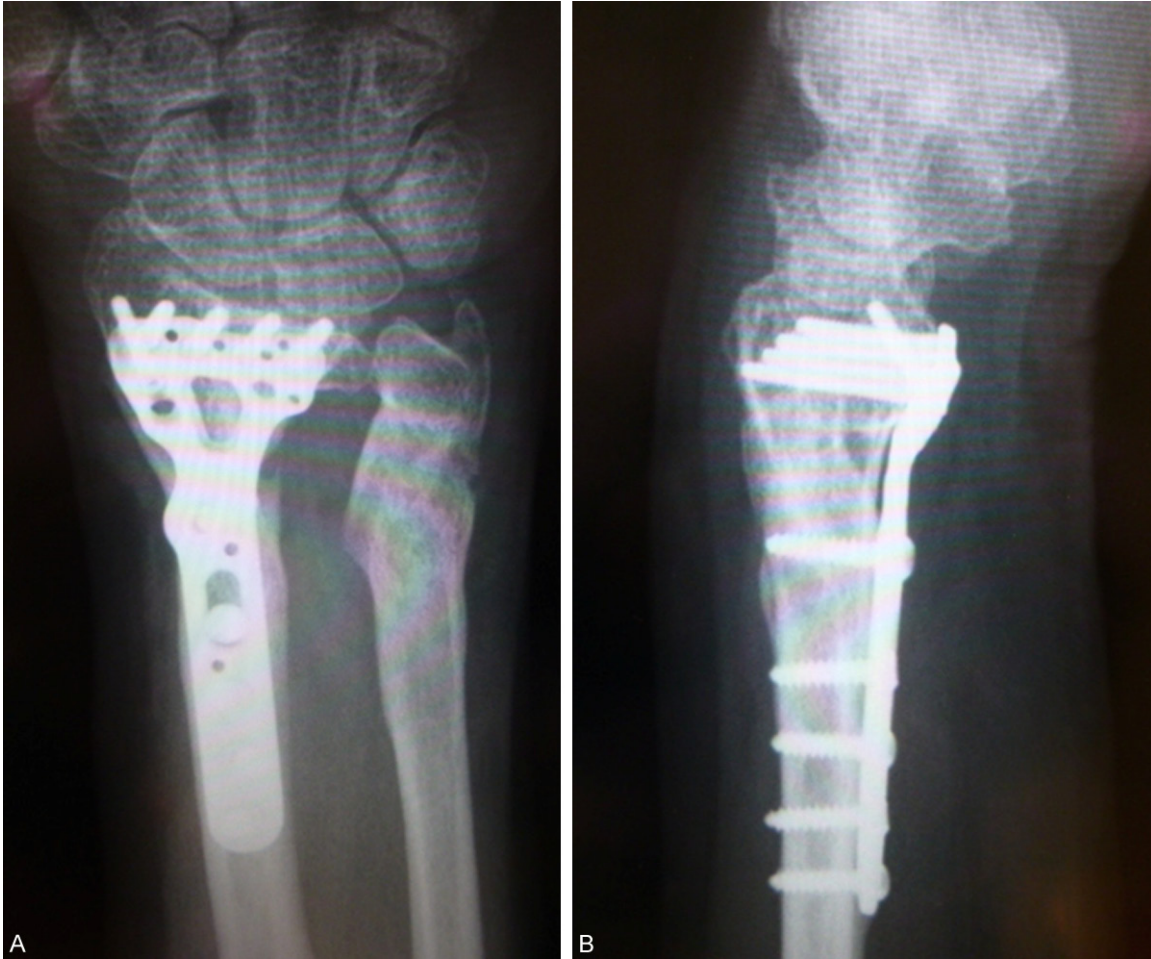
Plain radiography on the final follow-up. A: Frontal view on plain radiography. B: Lateral view on plain radiography. Favorable bone union was achieved in both the radius and the ulna, and the DRUJ alignment was also favorable.
